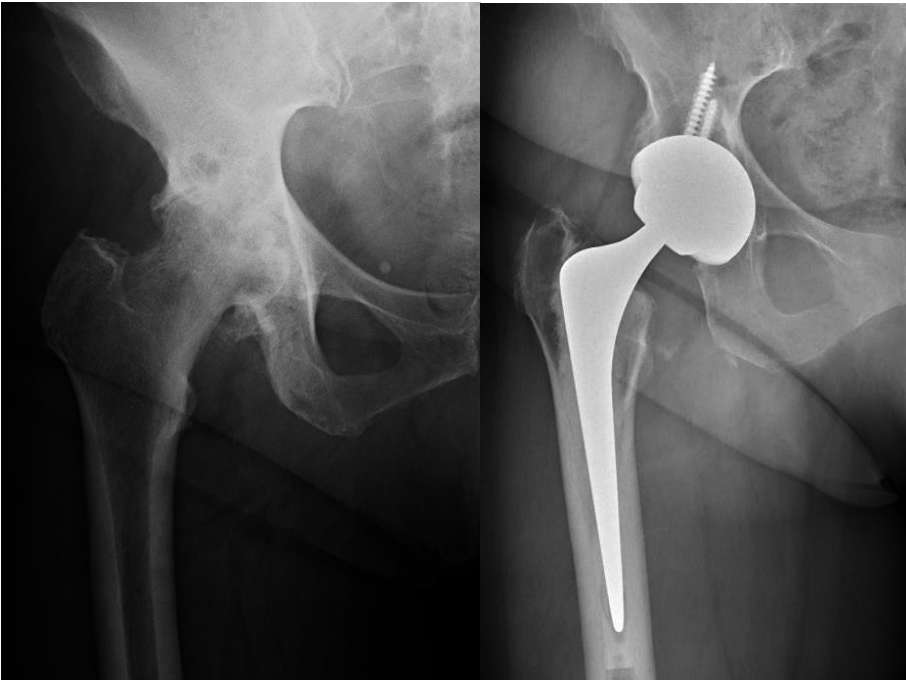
An AP radiograph of the right hip demonstrating severe hip osteoarthritis (OA) with joint space narrowing, osteophytes, subchondral sclerosis, and a subchondral cyst in the femur and acetabulum (left). A radiograph of the same hip after a hybrid THR procedure (right).
